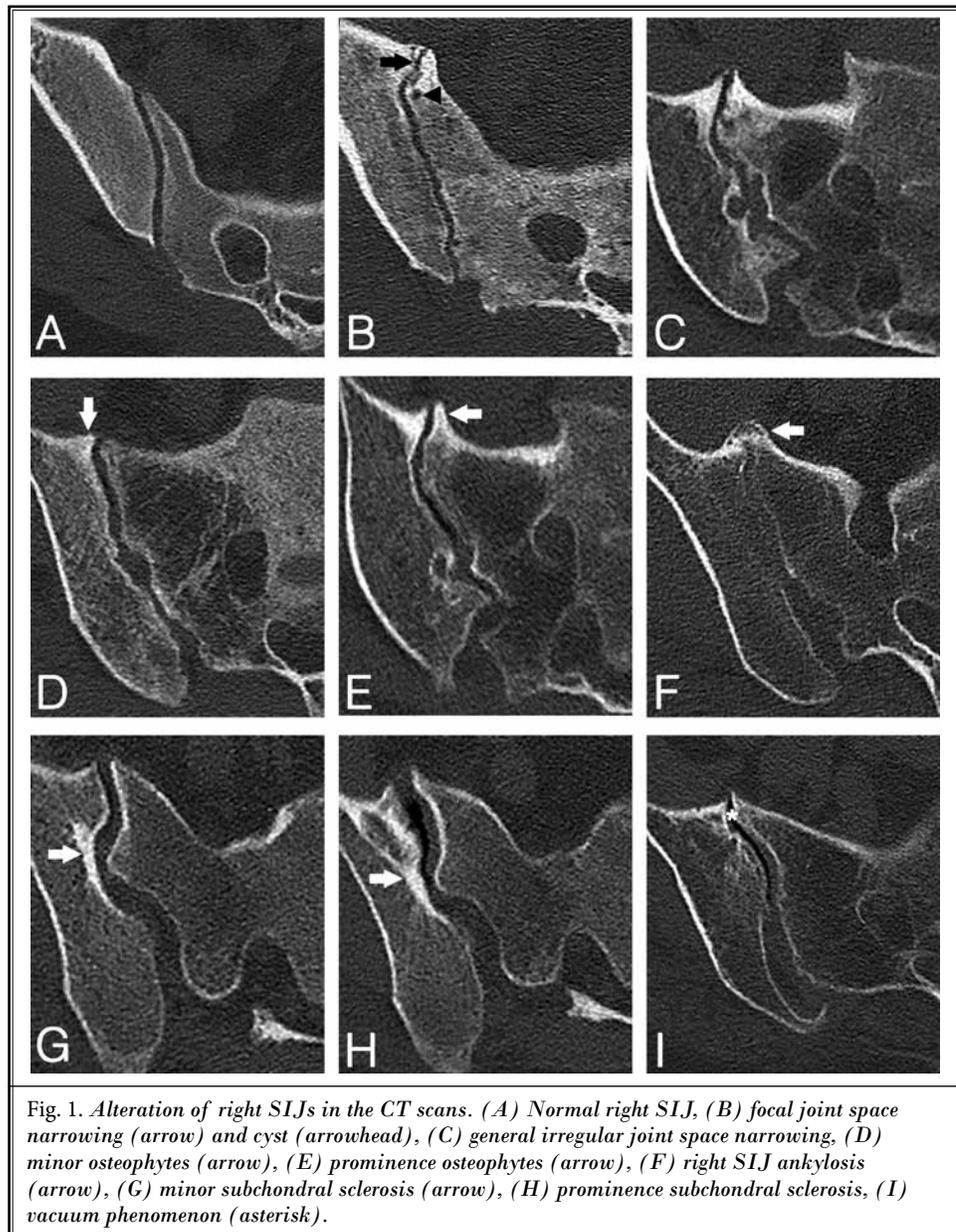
Alteration of right SIJs in the CT scans. (A) Normal right SIJ, (B) focal joint space narrowing (arrow) and cyst (arrowhead), (C) general irregular joint space narrowing, (D) minor osteophytes (arrow), (E) prominence osteophytes (arrow), (F) right SIJ ankylosis (arrow), (G) minor subchondral sclerosis (arrow), (H) prominence subchondral sclerosis, (I) vacuum phenomenon (asterisk).
